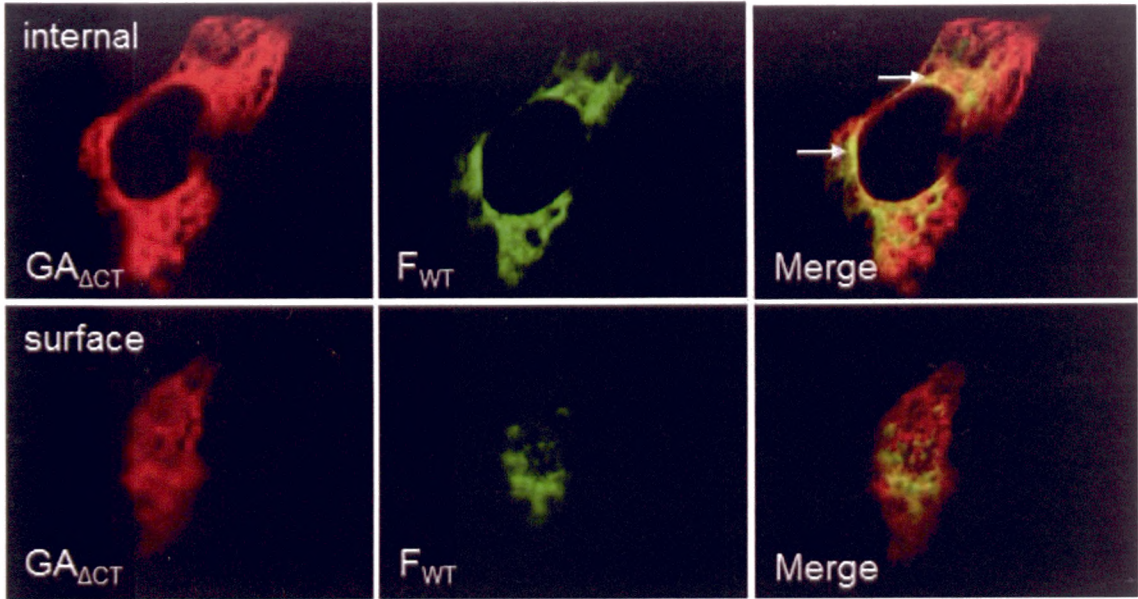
HEp-2 cells expressing wild-type F_{WT} protein and cytoplasmic tail-region deleted $GA_{\Delta CT}$ protein as seen by a 100X confocal objective. F protein is labeled with green dye FITC. GA protein is labeled with red dye Alexa Fluor 555. When both colours are combined (Merge), the yellow coloured areas represent co-localisation of F and GA proteins in the cells. The internal (top row) and surface (bottom row) views of the cells are shown. Arrows indicate areas of co-localisation around the nucleus.
